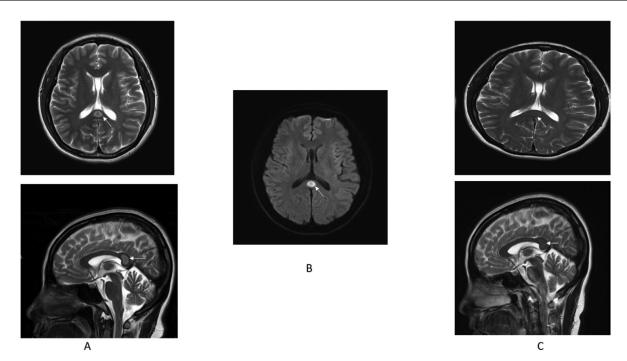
MRI of the brain of a 38 year old primigravida 2 weeks post delivery.
